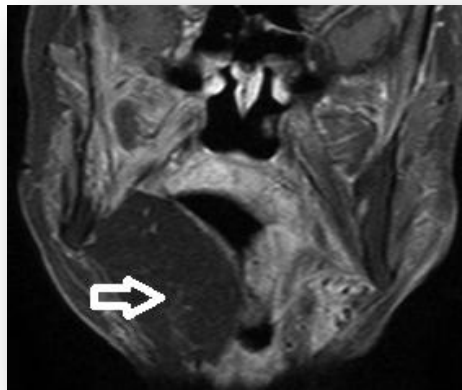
Reconstruction of the floor of the mouth and the right side of the tongue with a rectus abdominis Myocutaneous free flap (white arrow) in a 68-year-old female. Coronal contrast-enhanced fat-saturated T1-weighted MR image depicts the flap filling the surgical defect. The flap shows reduced signal intensity, which represents fatty replacement, without abnormal enhancement.
